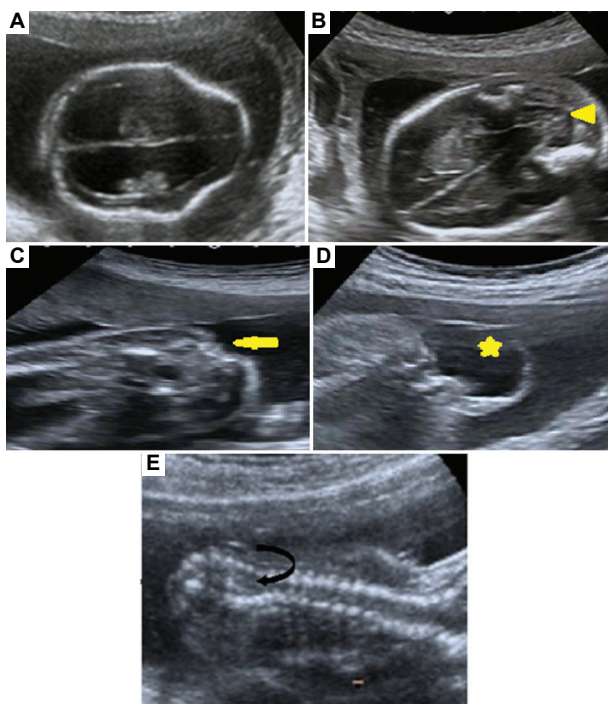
Multiplanar ultrasound images of a fetus with meningocele. (A) A “lemon-shaped” cranium. (B) A curved appearance of the cerebellum, known as “banana-sign” (yellow arrowhead). (C-E) Ultrasound images show a skin defect (yellow arrow), a meningocele sac (yellow star), and the separation of vertebral ossification centers (curved black arrow), respectively.
